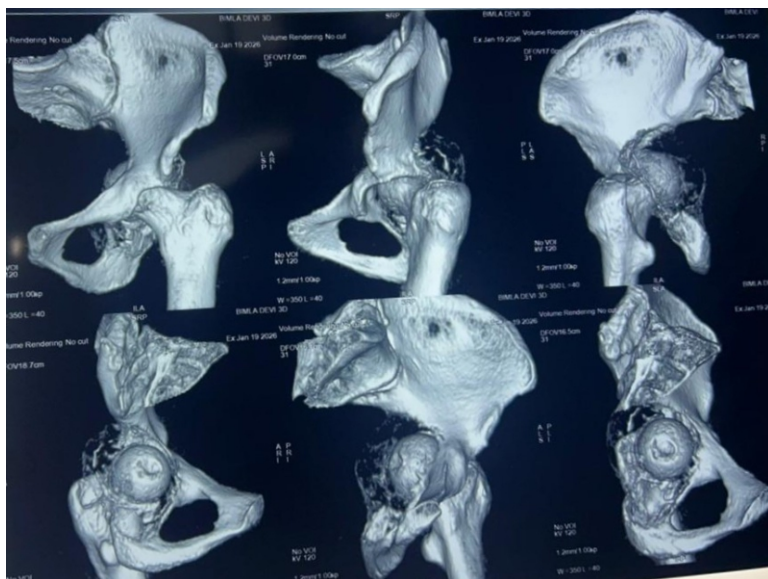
3D computed tomography scan demonstrating cortical thinning and breach of the acetabular walls, with involvement of the weight-bearing dome.
